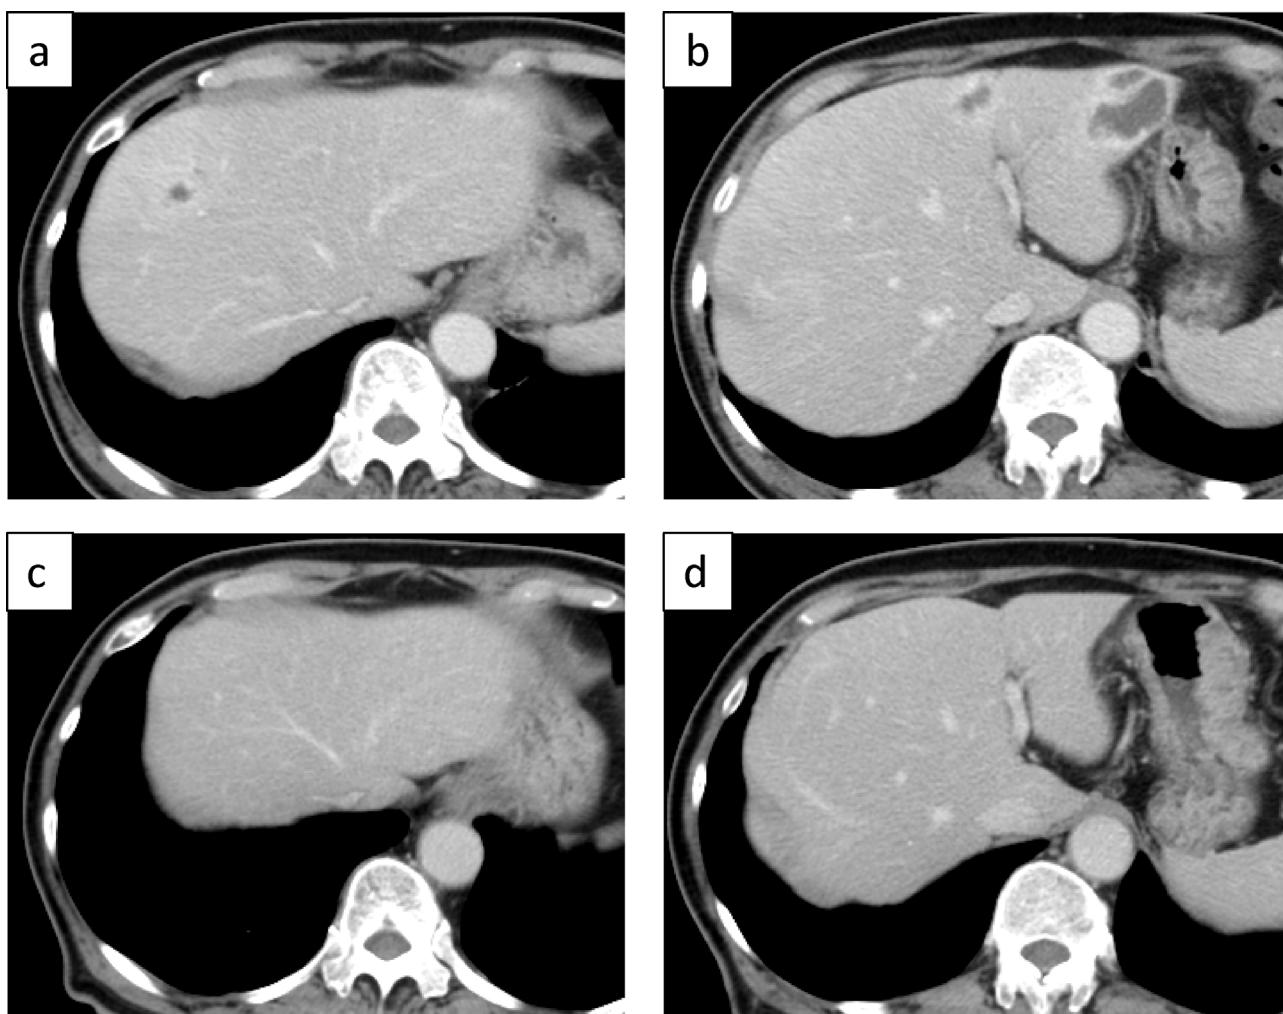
Computed tomography (CT) image.
